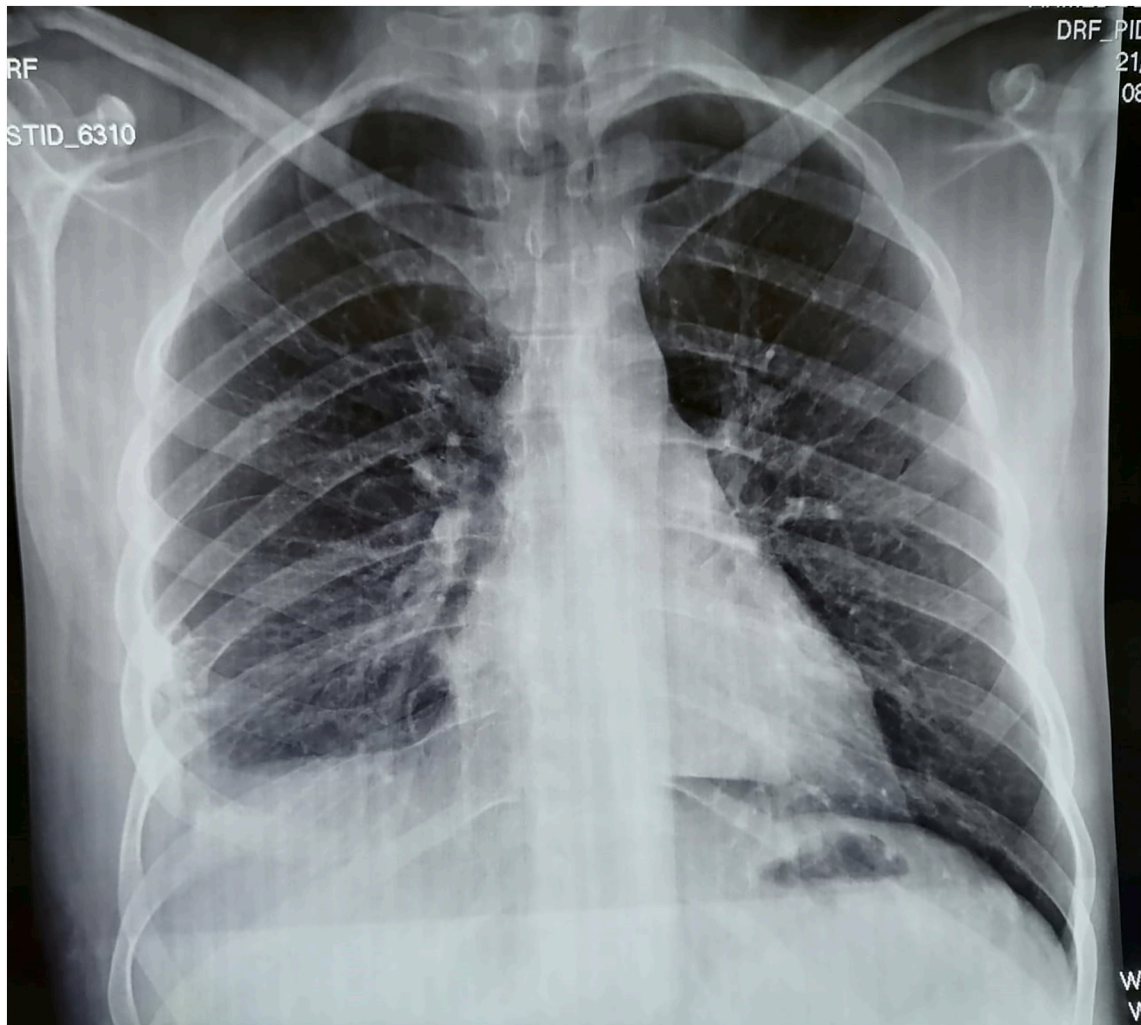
Control chest X-ray one month after surgery.
